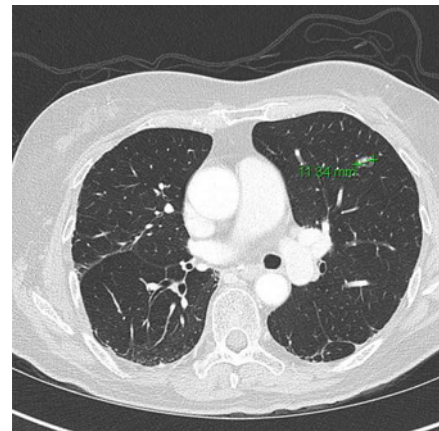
CT image showing recurrence of the lung adenocarcinoma.
